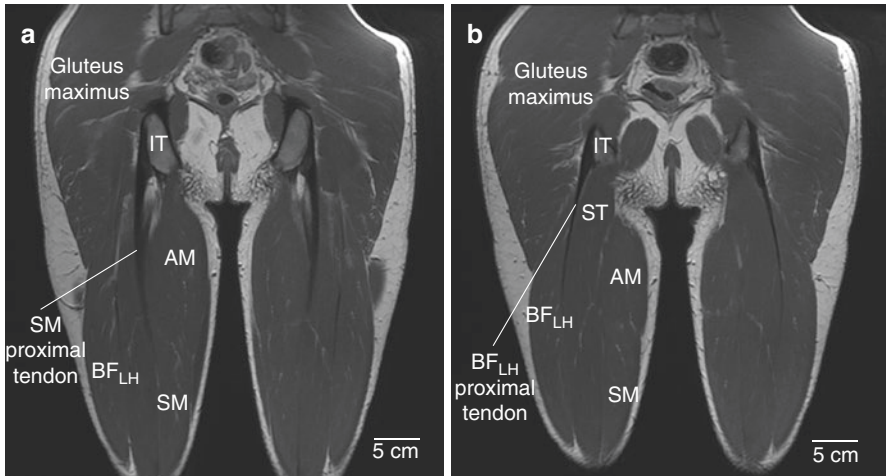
Proton density, coronal magnetic resonance images from a young man demonstrating the long tendons and musculotendinous junctions of (a) semimembranosus (SM) and (b) biceps femoris long head (BF_{LH}). AM adductor magnus, IT ischial tuberosity, ST semitendinosus
